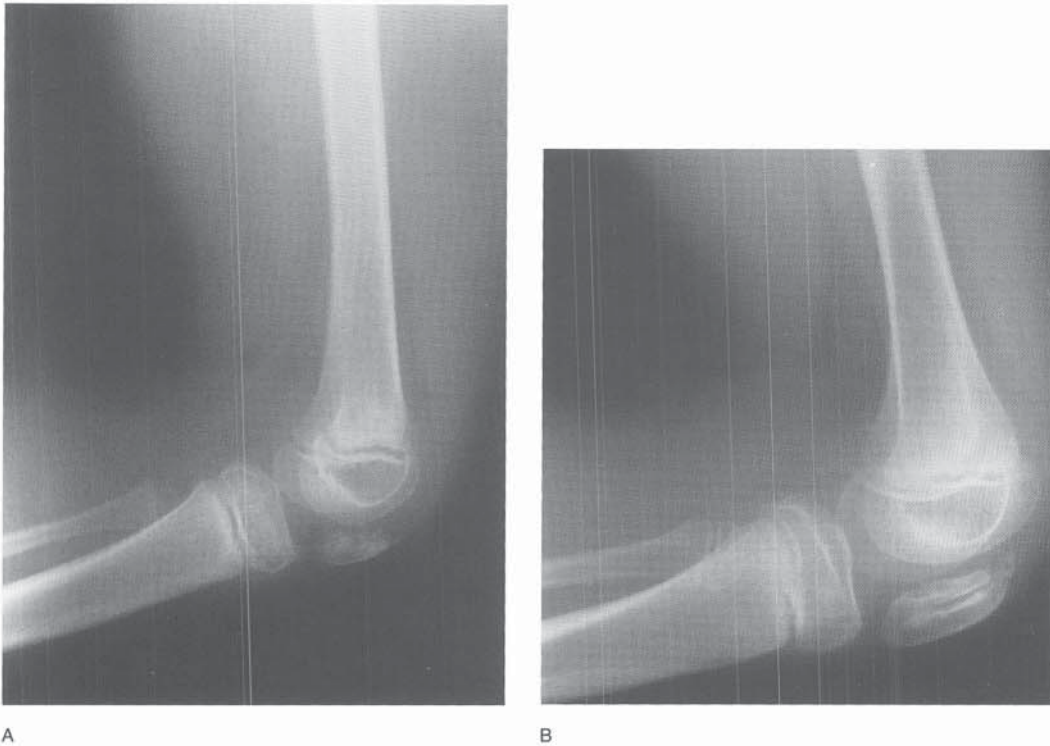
A, Lateral radiograph of the knee of a 5-year-old girl with multiple epiphyseal dysplasia. Ossification of the patella is irregular. B, By age 8, the patella appears to be double-layered.
